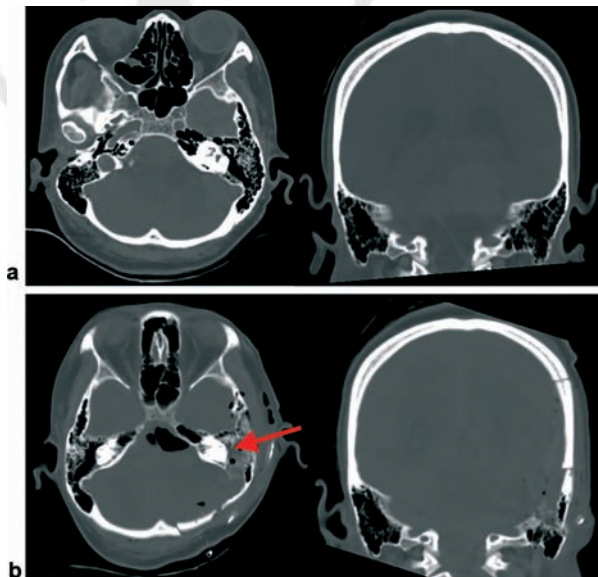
Comparison between preoperative (a) and postoperative (b) computed tomography scan showed the extent of the mastoid drilling. Note that the semicircular canal was preserved (*red arrow*).
